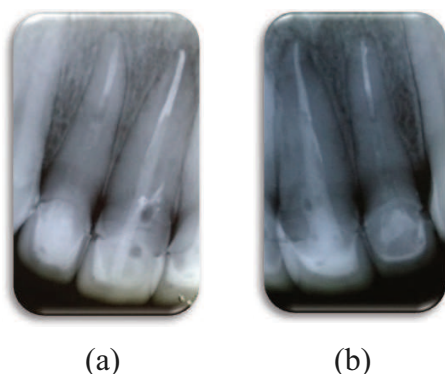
Radiograph periapical of the teeth 12,11 (a), and teeth 21,22 (b) after recalled and control 3 month after treatment. It has seen the lesion on periapical 11 and 21 are smaller.
